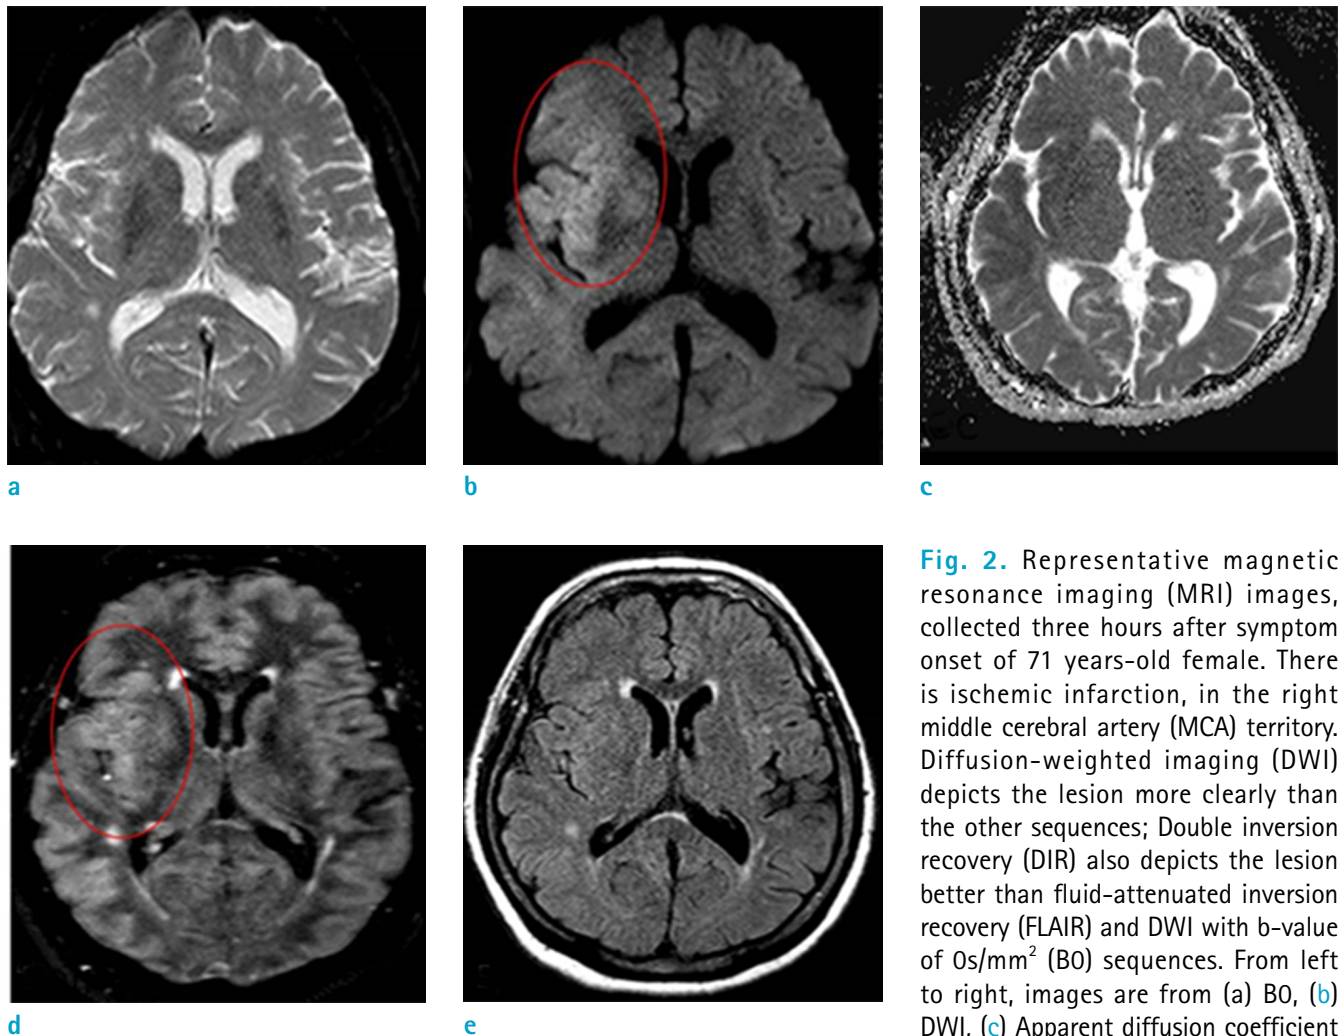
Representative magnetic resonance imaging (MRI) images, collected three hours after symptom onset of 71 years-old female. There is ischemic infarction, in the right middle cerebral artery (MCA) territory. Diffusion-weighted imaging (DWI) depicts the lesion more clearly than the other sequences; Double inversion recovery (DIR) also depicts the lesion better than fluid-attenuated inversion recovery (FLAIR) and DWI with b-value of 0s/mm^2 (B0) sequences. From left to right, images are from (a) B0, (b) DWI, (c) Apparent diffusion coefficient (ADC), (d) DIR and (e) FLAIR. Note that LNR values of each sequence are as follow: DWI = 32.8, DIR = 60.3, FLAIR = 10.2, and B0 = 22.2.
